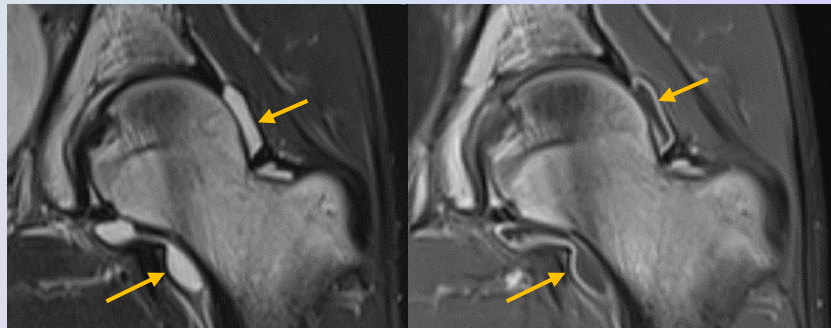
Coronal T2W MRI left hip showed moderate joint effusion (arrows).
